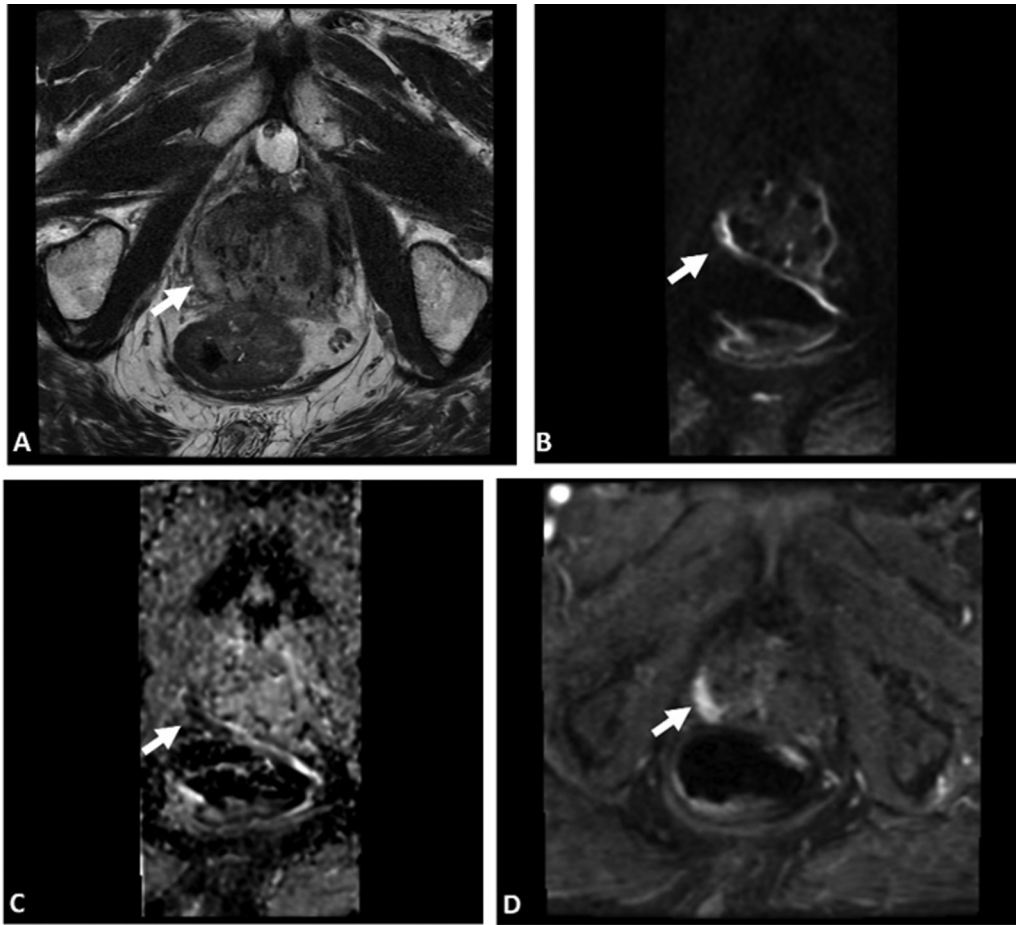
Multiparametric magnetic resonance imaging (mpMRI) in post-radiation therapy (post-RT) recurrence. mpMRI in a 93-year-old patient with biochemical recurrence (prostate-specific antigen [PSA] 9.36 ng/mL) 22 years after brachytherapy for prostate cancer showing (A) a 2.2-cm T2 hyperintense lesion in the right posterior lateral peripheral zone mid-gland, also showing (B,C) diffusion restriction and (D) early arterial enhancement on dynamic contrast enhanced (DCE), suspicious for recurrence (arrows).
